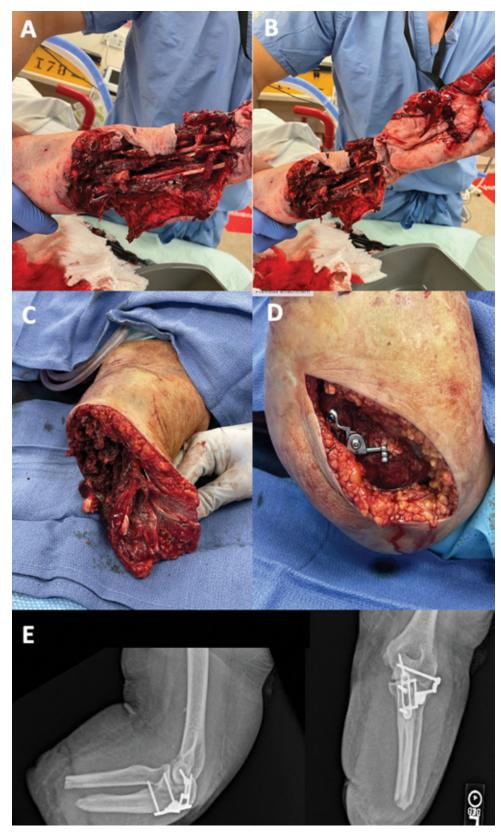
(A&B) Significant degloving injury to the left upper extremity upon presentation to the trauma center; (C) Our patient's extremity after debridement and application of negative pressure wound vacuum; (D) Placement of internal joint stabilizer in the left elbow; (E) Six-week postoperative x-rays demonstrate stable alignment of the internal joint stabilizer and concentric reduction of the elbow joint.
